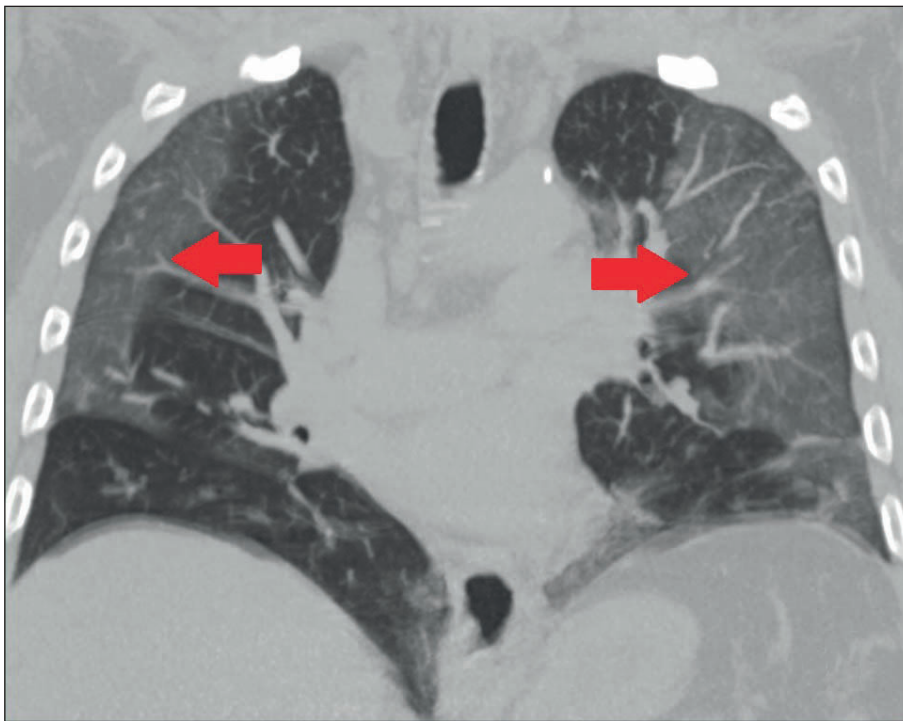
Coronal section of high-resolution CT of the chest showing ground glass opacities in the periphery of both lungs in a patient with COVID-19 (red arrows).
